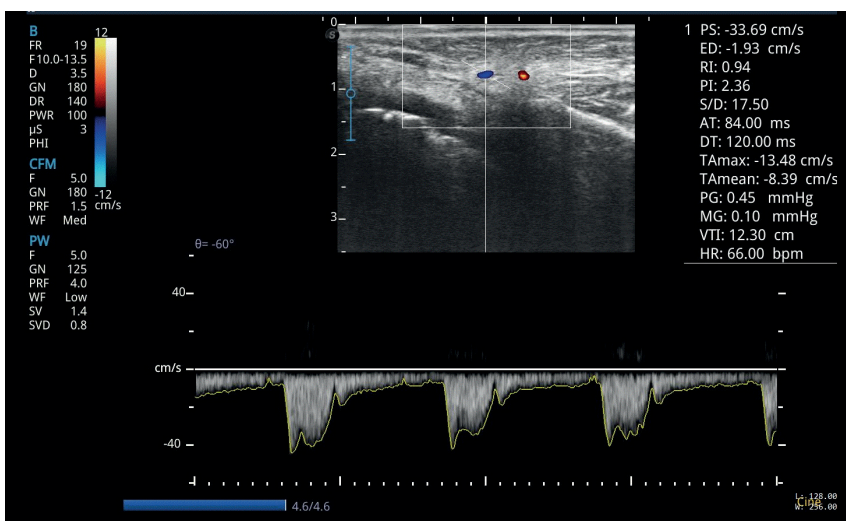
Doppler of patient B. the subgroup G. 1.1 of the main group, 6 months after the beginning of treatment
